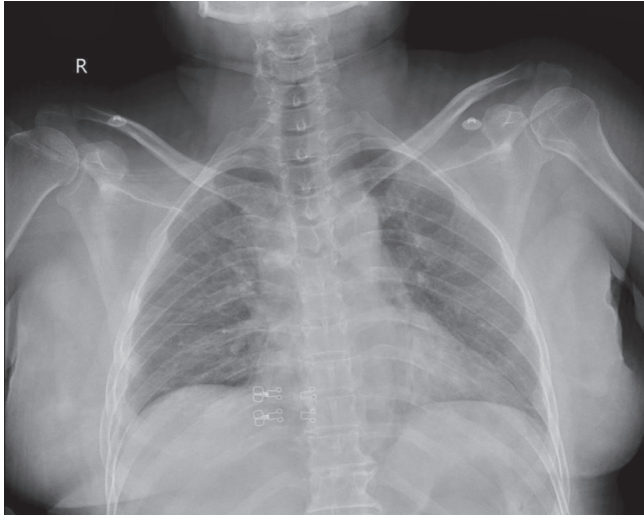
Posteroanterior chest radiography revealing 3rd, 4th, 5th, and 6th rib fractures on the right side on the day of the accident.
